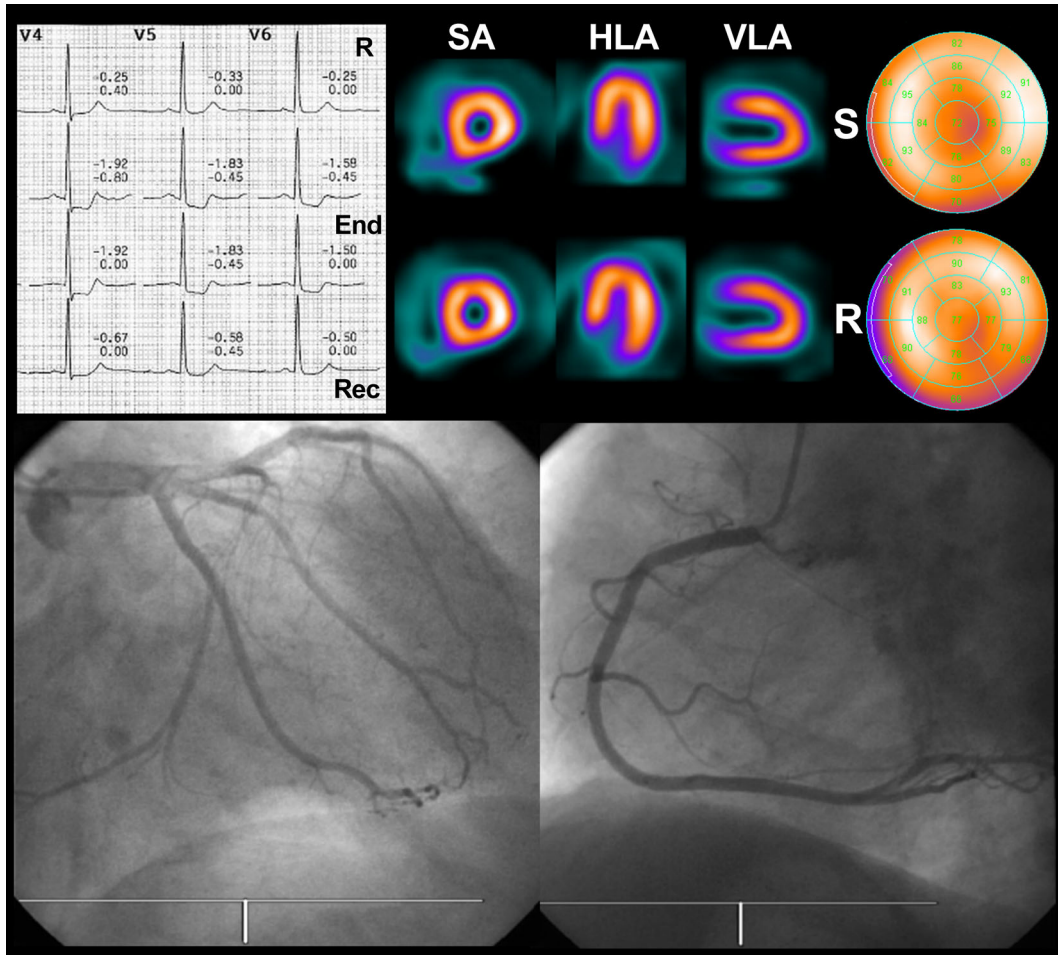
Normal myocardial perfusion SPECT of a woman with downsloping ST-segment depression at the end of exercise test, and normal coronary angiography. *HLA*, Horizontal long axis; *R* rest; *Rec*, recovery; *S* stress; *SA* short axis; *VLA* vertical long axis.
